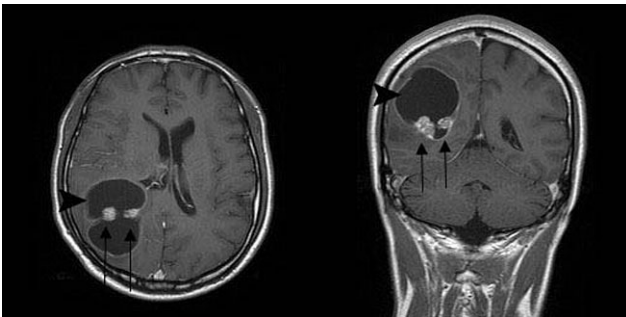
T1-weighted axial (left) and coronal (right) MR images with gadolinium enhancement revealed a well-defined cystic lesion (arrowheads) measuring approximately 6.0×4.8 cm. The lesion was located over the right fronto-parieto-occipital region, with enhancement in 2 solid compartments (arrows). Perifocal edema from the tumor with a mass effect effaced the cortical sulcus and compressed the posterior horn of the right lateral ventricle.
